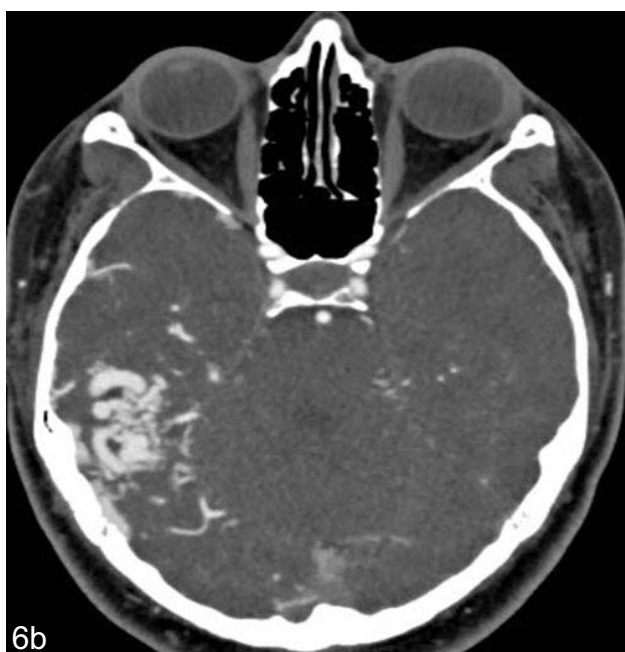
Showing subtle hyperdensity in right temporal lobe on non contrast CT head. 6b: Postcontrast CT shows AVM corresponding to hyperdense area in right temporal lobe.
